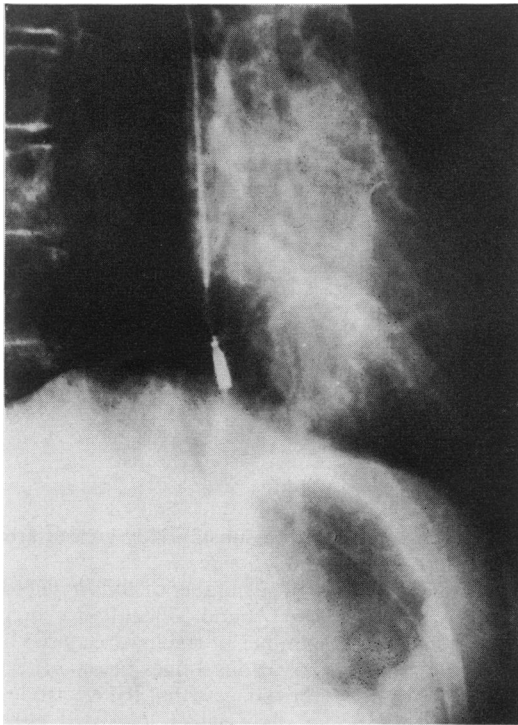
Oblique radiograph in the sitting position. No alteration in the position of the electrode is seen compared with Figure 3.
